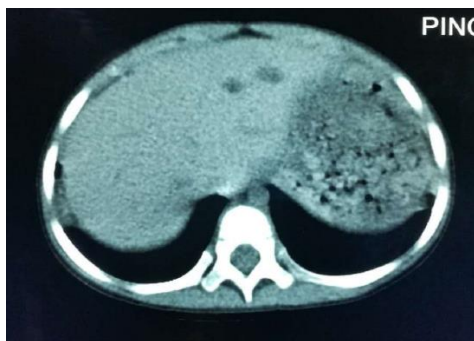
Liver CT scan of the CF patient. Liver CT scan revealed a low-density lesion in the left lobe of the liver.
